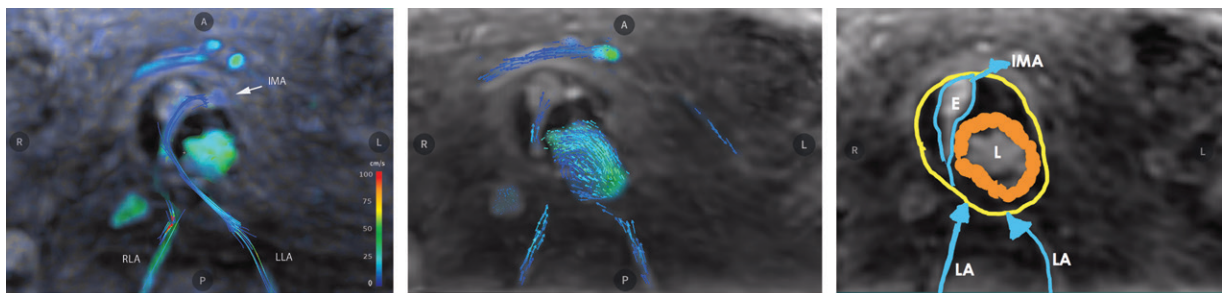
Four-dimensional flow MRI after endovascular abdominal aortic aneurysm repair. (a) Image with streamlines shows that both L3 lumbar arteries and the inferior mesenteric artery (*IMA*) are involved in a type II endoleak. (b, c) Image with velocity vectors (b) allows subclassification of the endoleak as type IIb, with two inflow branches (both lumbar arteries) and one outflow branch (*IMA*) (c). *E* = endoleak, *L* = aortic lumen, *LA* = lumbar artery.
